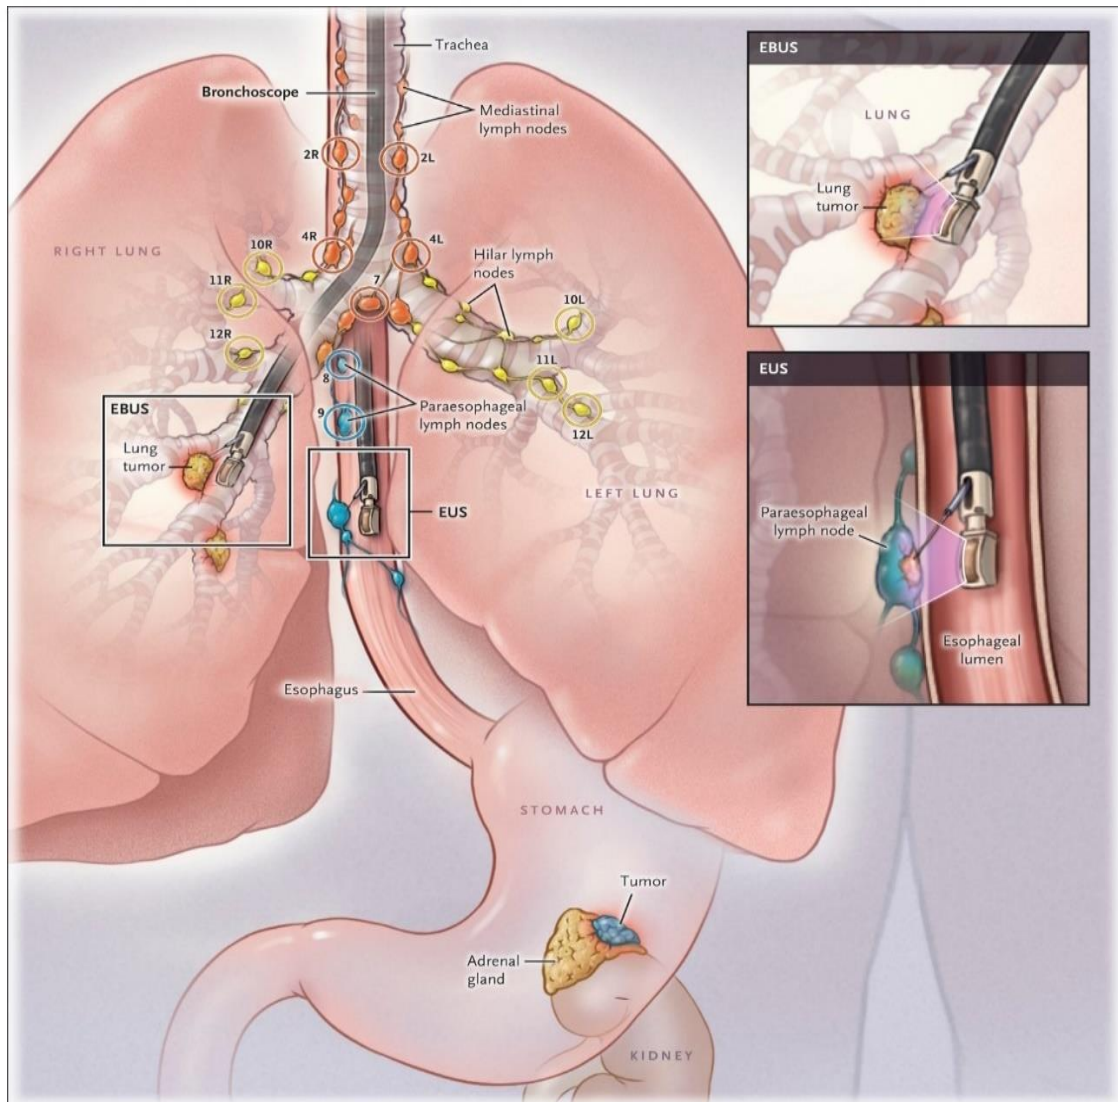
Endoscopic diagnosis of lung cancer. Endoscopic bronchial ultrasonography (EBUS) and endoscopic esophageal ultrasonography (EUS) are endoscopic techniques for detecting lung cancer, lymph node metastases, and adrenal metastases (79).
